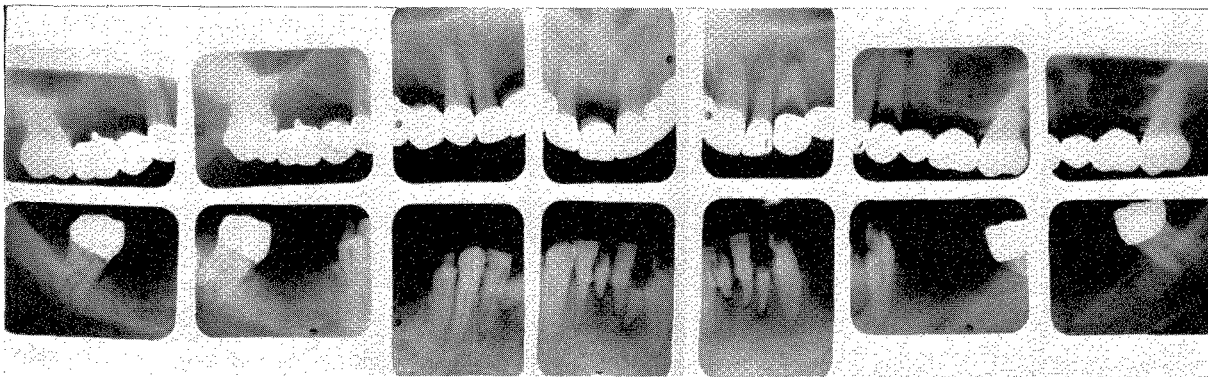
Roentgenograms showing the neglect which could have been prevented had regular checkups been instituted. The photograph of the mouth is shown in Fig. 739.
